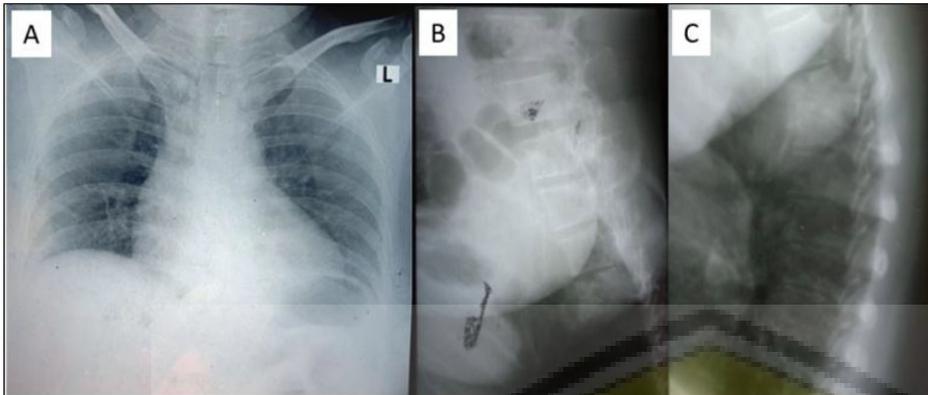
Plain X-ray. A. thoracic anteroposterior. B, C. Thoracolumbal spine in lateral view.
